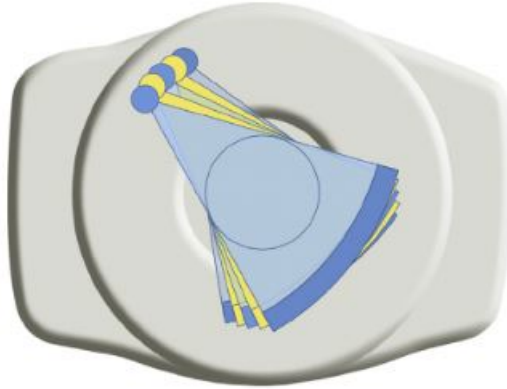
Single source CT, using rapid kVp switching [18].
